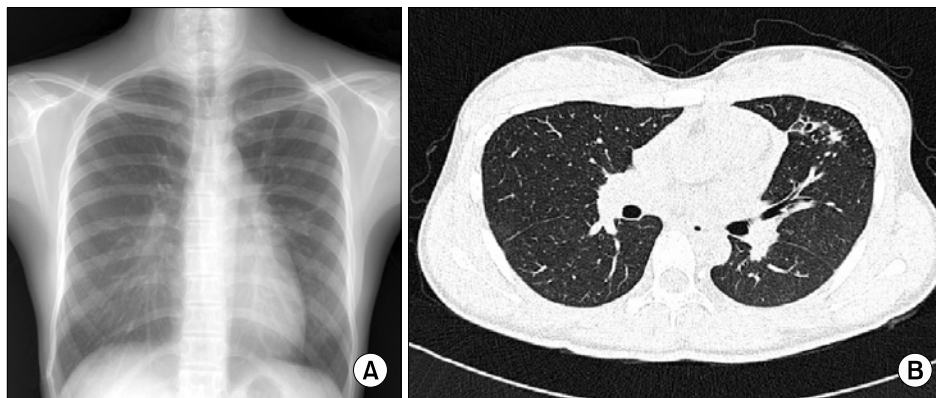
(A) On admission, chest radiography shows multiple nodular lesion at left upper lobe. (B) High resolution computed tomography of the chest shows cystic lesions and ground glass opacities at left upper lobe.
